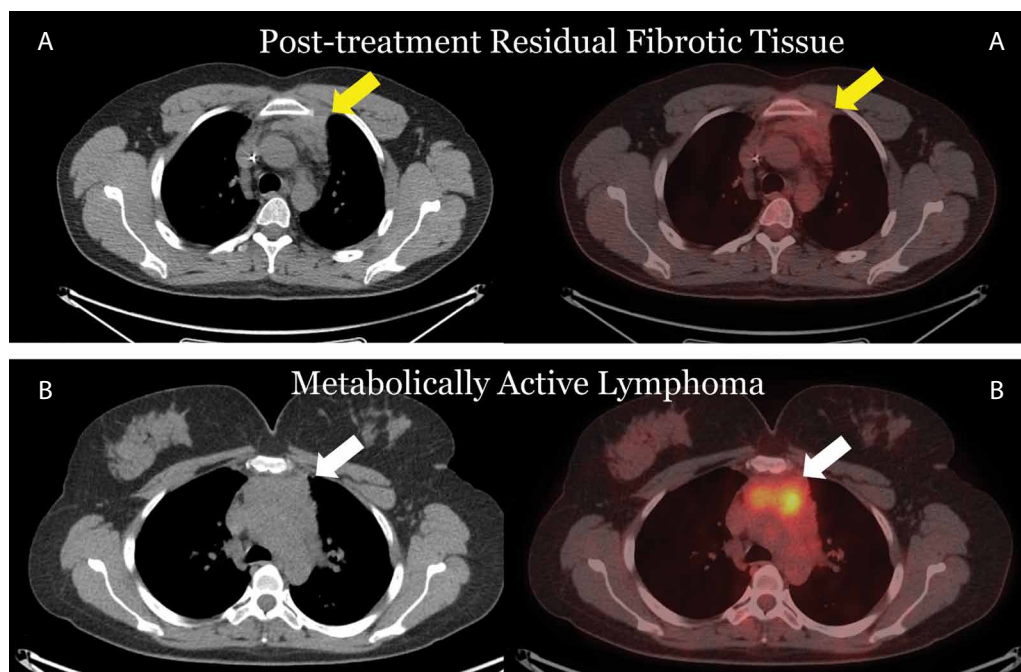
Hodgkin's Lymphomas post treatment. A. Treatment response with residual anterior mediastinal mass not showing increased FDG uptake (yellow arrow). B. Case of residual active disease with lobulated mediastinal soft-tissue mass showing increased metabolic activity (white arrow).
